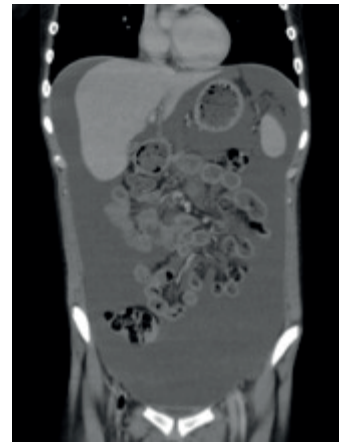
CT image of the persistent resistant acid during adjuvant treatment
